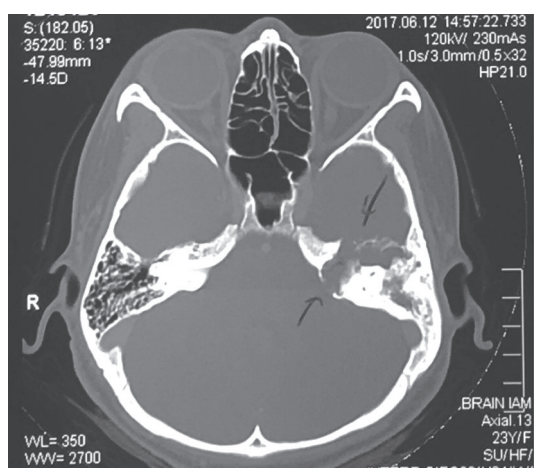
MRI brain and IAM. Shows bony expansion of the petrous bone with soft tissue lesion in the tympanic cavity and attic.
